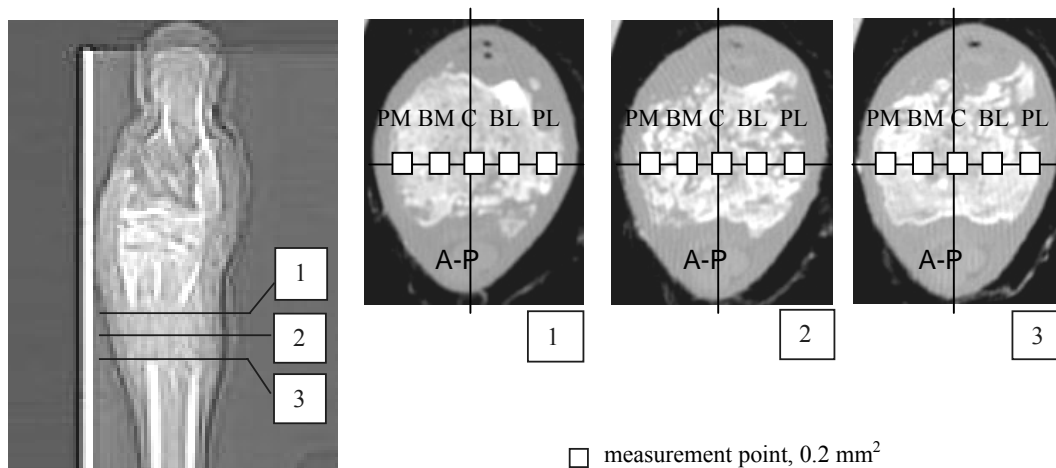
Typical CT scan of totally elongated metatarsal and localization of measurement areas – CT slice (1, 2, 3)
